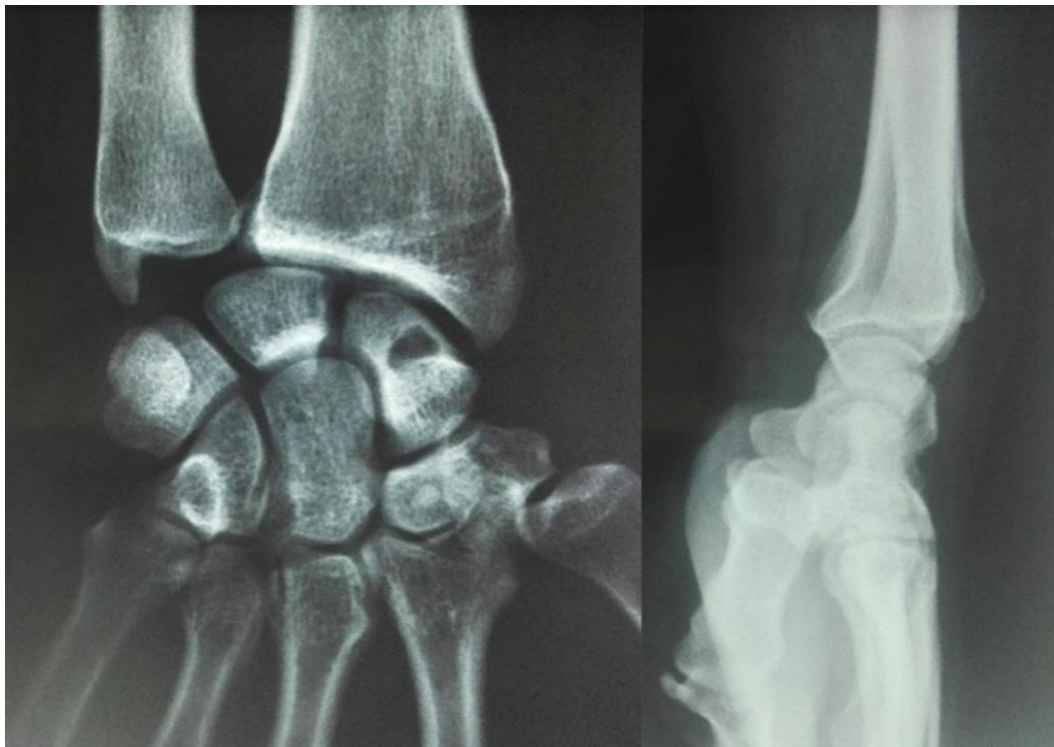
Plain radiographs of the left wrist revealed a radiolucent cystic lesion of the scaphoid without any fracture, loss of joint space or degenerative changes
